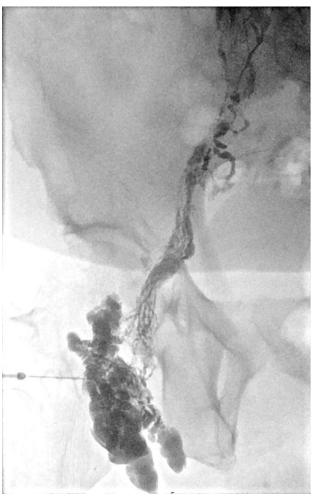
Intranodal ultrasound-guided puncture of inguinal lymph node and fluoroscopic controlled injection of Lipiodol® ultra-fluid.
